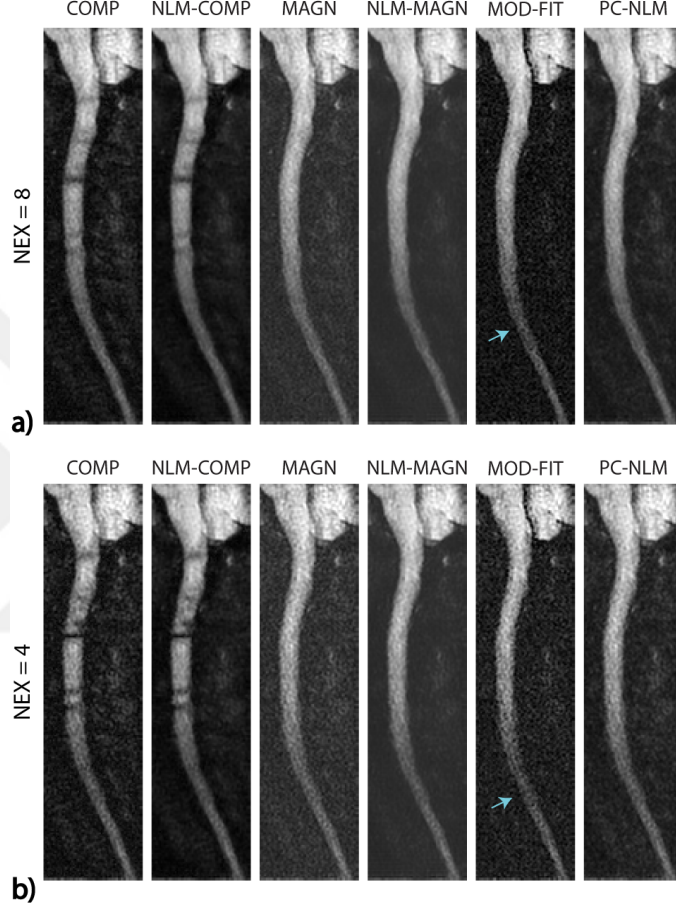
Results for in vivo DWI of the spinal cord for the first subject, for a) NEX=8 and b) NEX=4 (i.e., using only a subset of the 16 acquisitions). As NEX is reduced, the image qualities for COMP, NLM-COMP, and MOD-FIT significantly deteriorate. The number and extent of signal cancellation regions are increased for COMP and NLM-COMP, as the likelihood of having a NEX with similar phase is reduced when there are fewer NEXs. The image quality for MOD-FIT especially suffers in inferior parts of the spine (shown by blue arrows) due to reduced coil sensitivities. This problem is further exacerbated as NEX is reduced, as model fitting becomes more challenging when there are fewer samples for a low-SNR pixel. MAGN, NLM-MAGN, and PC-NLM show lower SNR with reduced NEX, but the image qualities are not affected otherwise. Overall, when compared to the other reconstruction techniques, PC-NLM has visibly improved image quality at both NEX=8 and NEX=4, and it does not suffer from local signal cancellations or noise accumulation problems.
